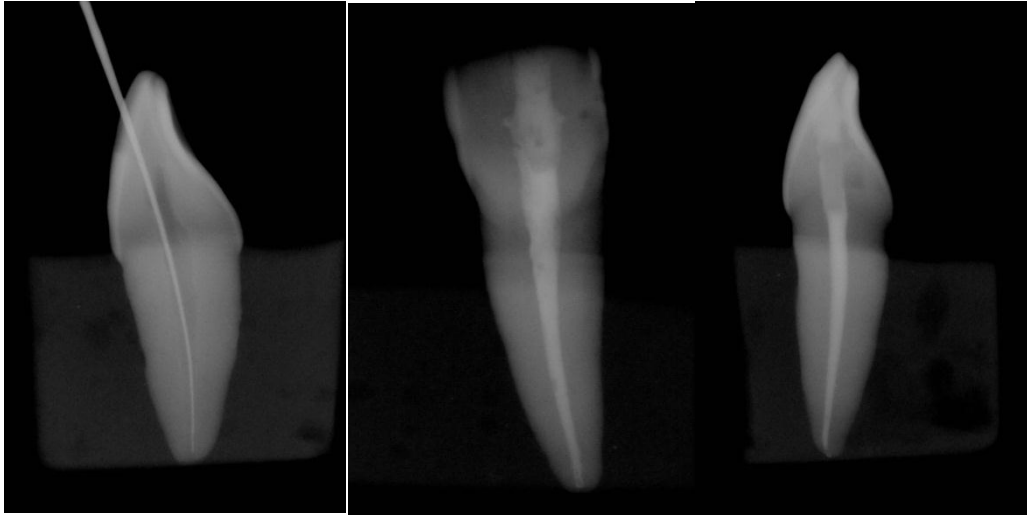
Radiographs Showing Working Length Determination And Obturation Through Labial Access Cavity
